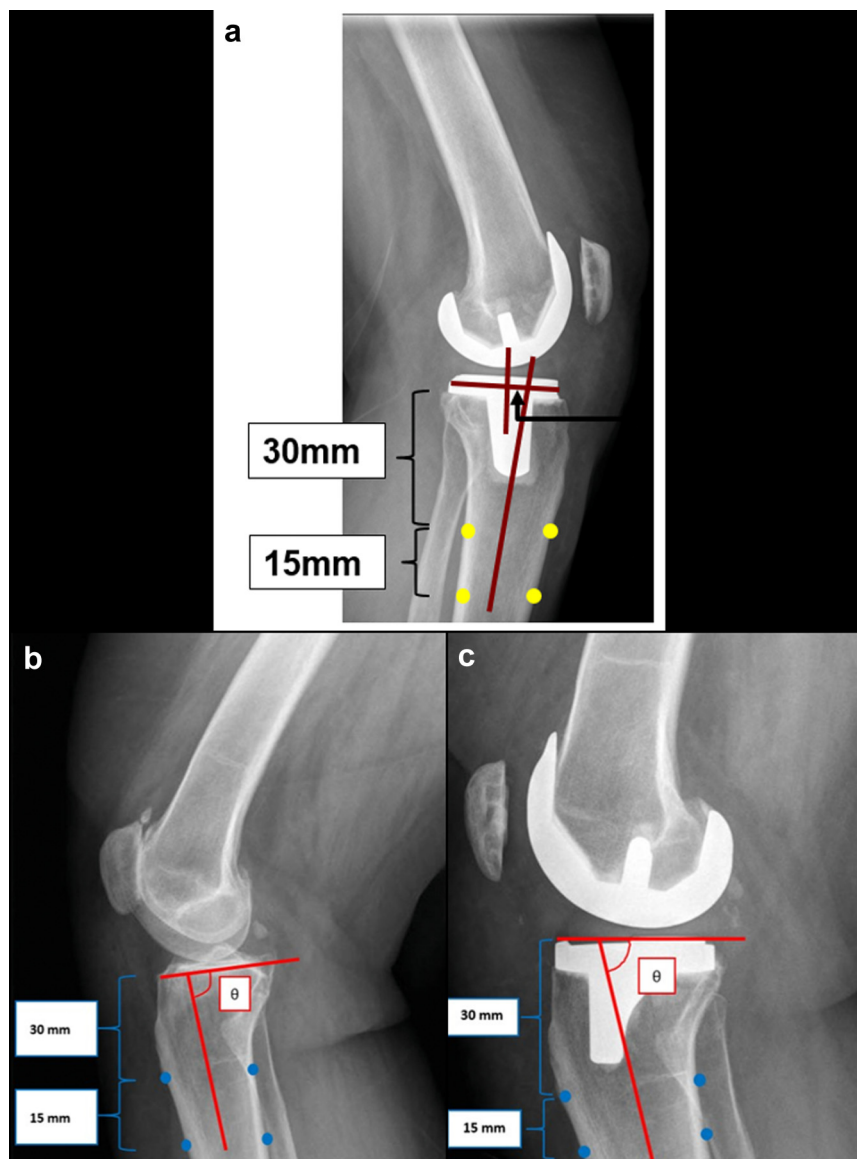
Radiographic measurements for (a) anteroposterior tibial baseplate position, (b) preoperative posterior tibial slope, and (c) postoperative posterior tibial slope.
